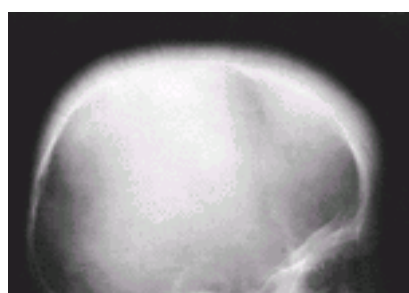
X-ray of the skull. In the frontal area, the bone has a lamellated structure, parallel to the inner table of the diploë. In the parietal area, erythroid hyperplasia has perforated the outer table, producing a characteristic "hair-on-end" appearance. (Courtesy of Dr. C. Orzincolo.)
